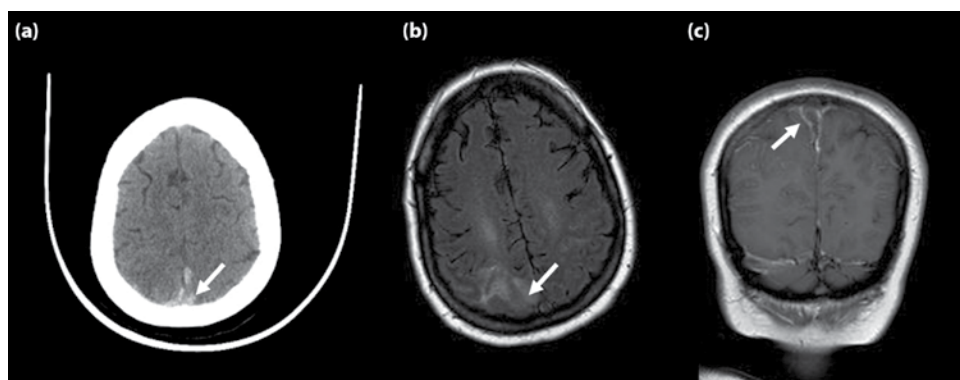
(a) CT image of the superior sagittal sinus thrombosis; (b and c) are MRI views of the lesion.
